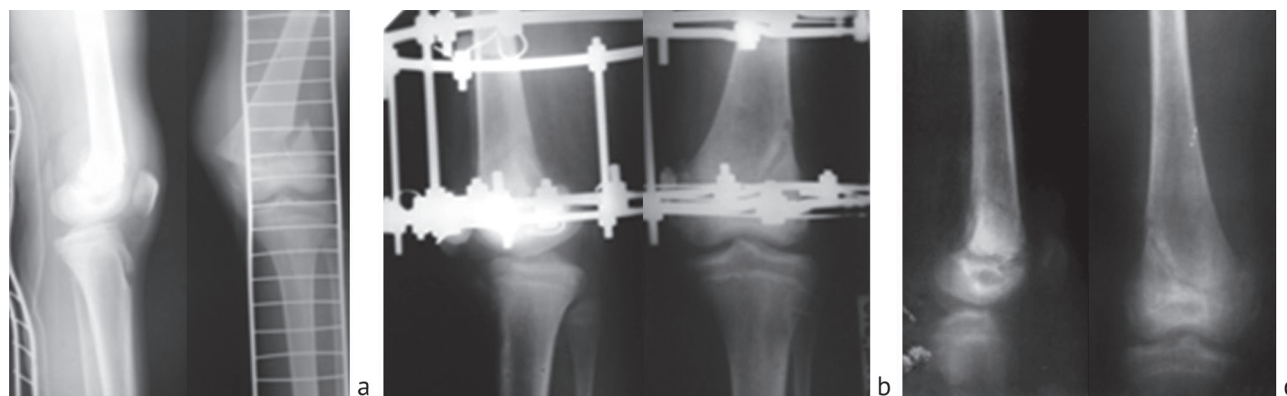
Closed fracture of the distal epimetaphysis of the femur (SH II). Radiographs taken in two projections: *a* before the operation; *b* after Ilizarov osteosynthesis; *c* after dismantling the Ilizarov apparatus
